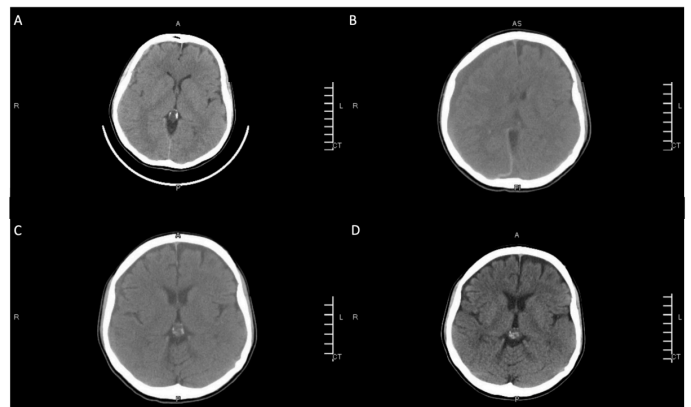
Serial Head CTs. A) Admission CT. B) Post worsening Symptoms. C) Post Procedure. D) Two Week Follow-up.
